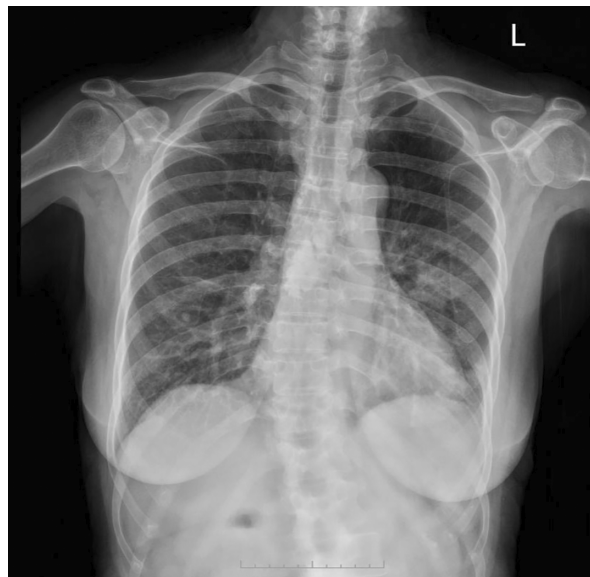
The initial chest x-rays showed patchy consolidations in both lungs and bronchiectasis (tram track sign) in the right lobe.
